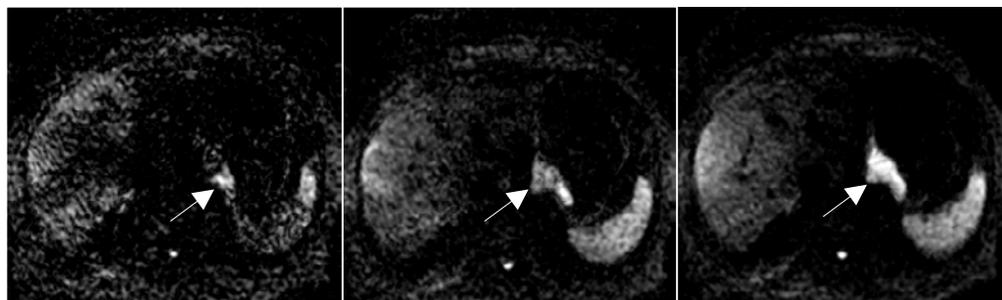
Demonstrating image quality of DW-MRI sequences with different NEXs. (c) NEX=4 showed more uniformity in tumor signal and less artifacts than (a) NEX=1 and (b) NEX=2.
